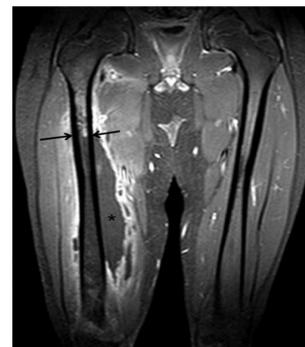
and 2B Gadolinium-enhanced fat-suppressed T1-weighted magnetic resonance images demonstrating osteomyelitis of the distal femoral metaphysis in an eight-year-old boy (Patient 8) who later developed a pathologic femoral fracture. Fig. 2A Axial image demonstrating a subperiosteal abscess encircling >50% of the bone circumference (arrows). Fig. 2B Coronal image demonstrating a sharp demarcation (arrows) between poorly enhancing abnormal marrow distally and relatively normally enhancing marrow proximally. Note the subperiosteal and muscle abscess (asterisk).
